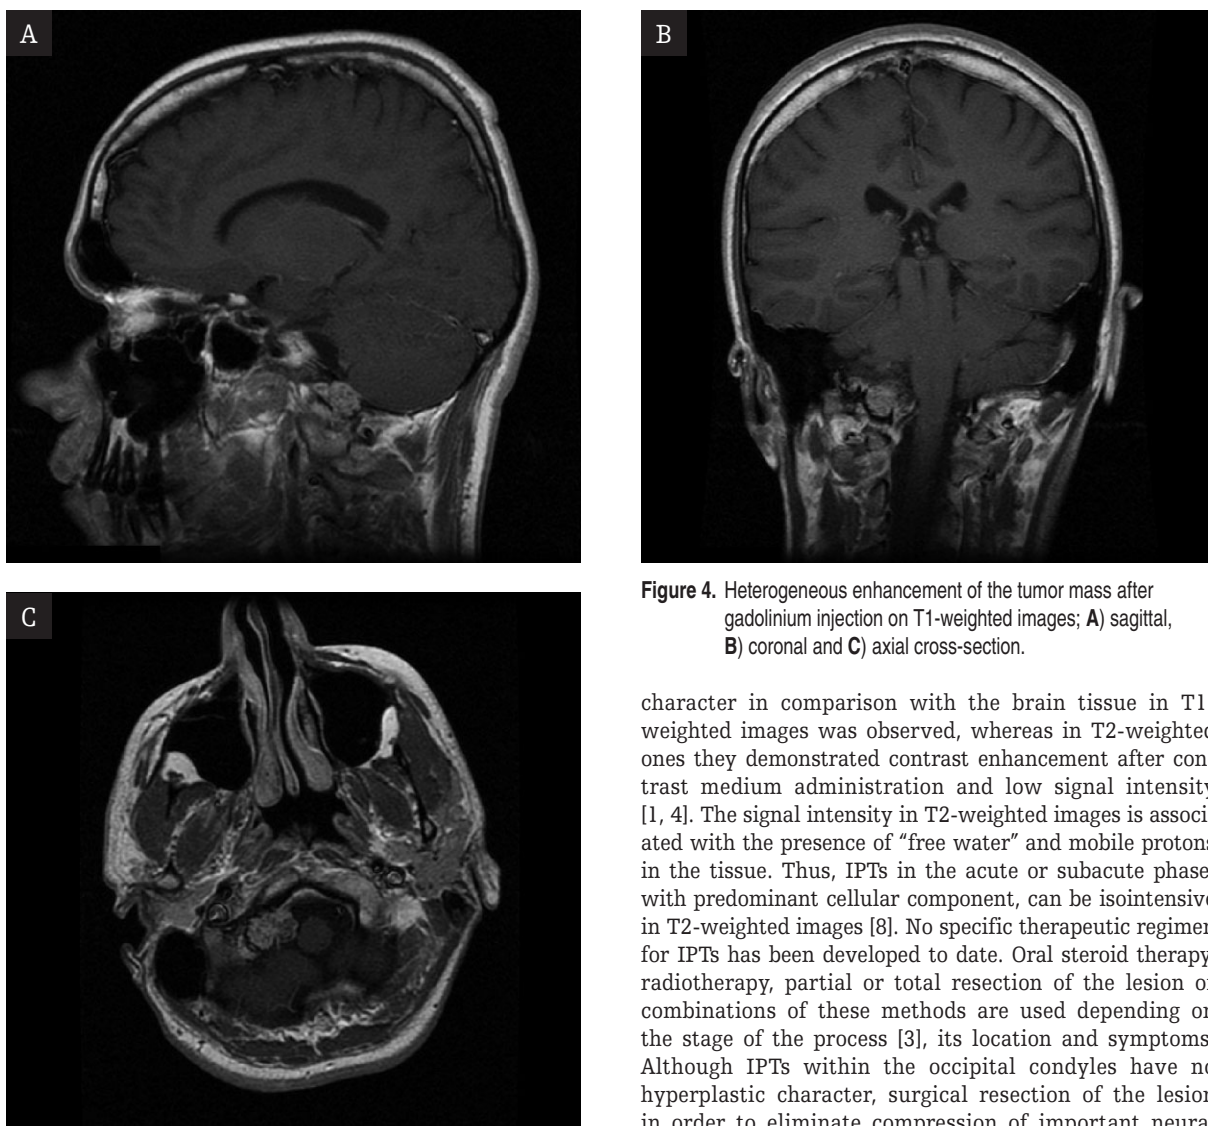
Heterogeneous enhancement of the tumor mass after gadolinium injection on T1-weighted images; A) sagittal, B) coronal and C) axial cross-section.
